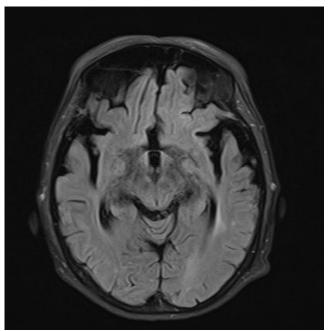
Flair image of first MRI scan presenting intensity changes at temporomesial and limbic areas
